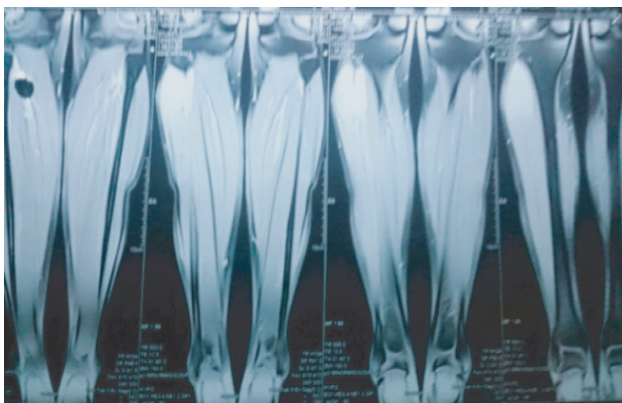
MRI image showing a heterogeneous and hyper intense tumoral process occupying the upper third of the right leg.
